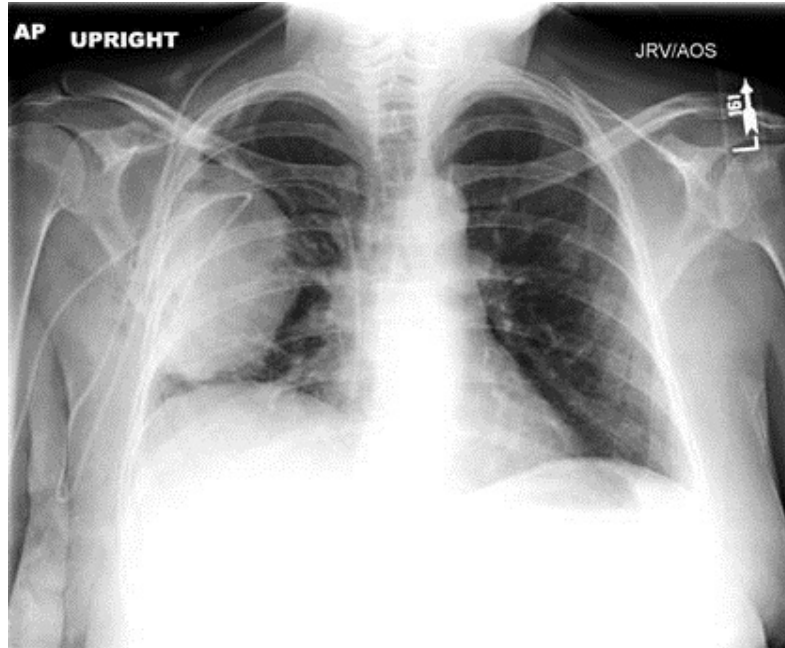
Chest X-ray showing the 'CSFoma' in the right pleural space. The shunt can be traced to the lesion. Also seen is a right-sided peripherally inserted central catheter (PICC) line.
